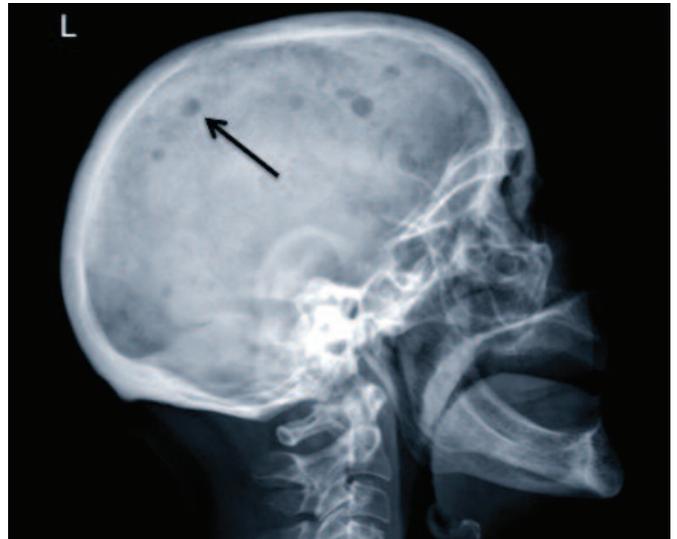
Lateral skull x-ray showing several well-circumscribed, radiolucent lesions superiorly (see arrowhead), consistent with myelomatous disease (classical ‘raindrop’ or ‘pepper-pot’ skull appearance).
